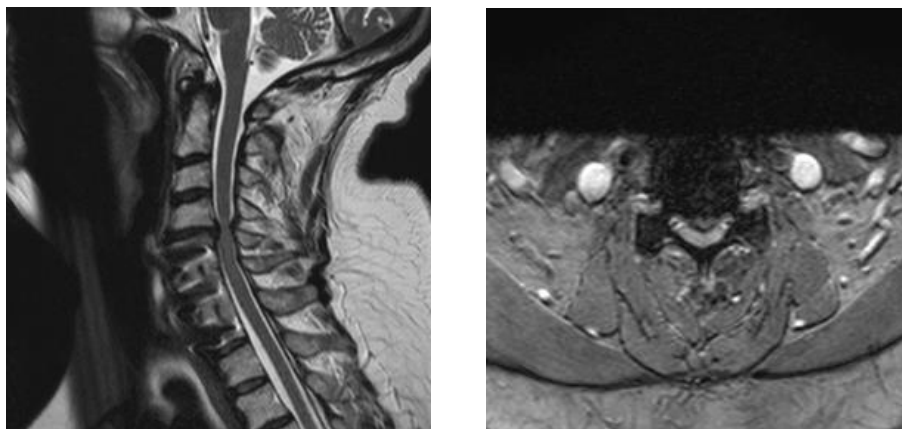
MRI showing cord compression at C4-5.
